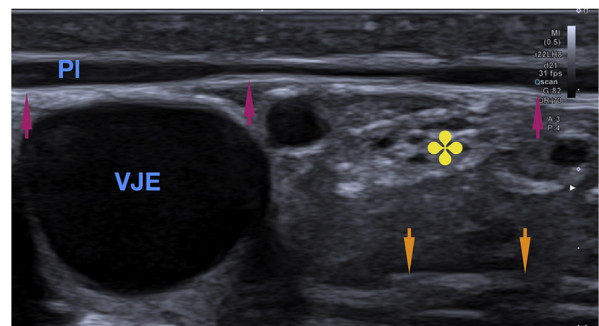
A 22 MHz sonogram of the neck: the different fascia layers as well as the supraclavicular nerves (yellow asterisk) coursing between the superficial (magenta arrows) and prevertebral (golden arrows) fascias are clearly visible. VJE: external jugular vein, Pl: platysma.
